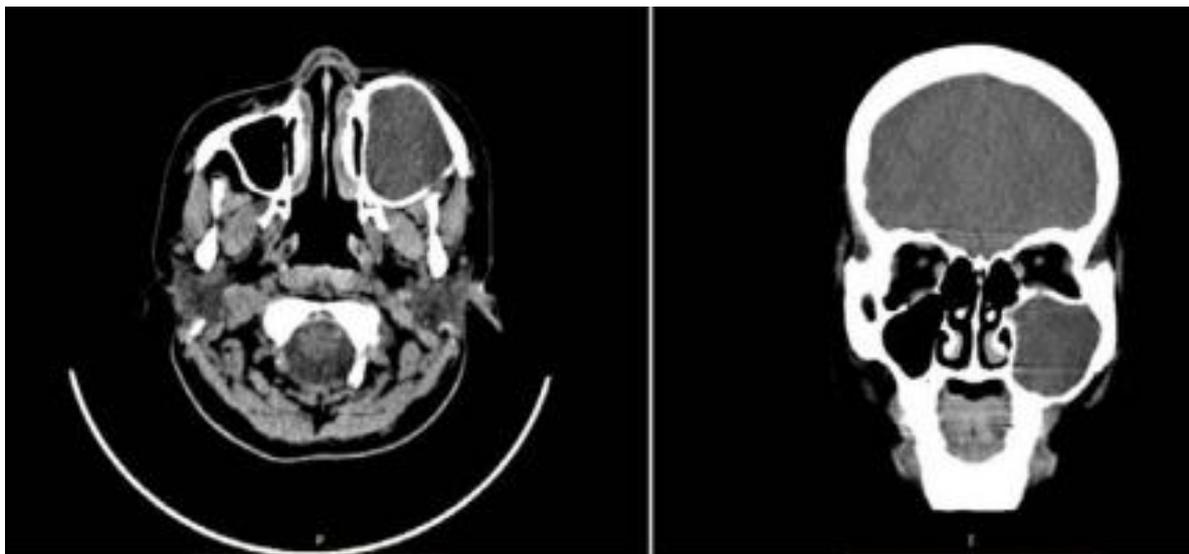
Coronal CT scan with left maxillary mucocele.
